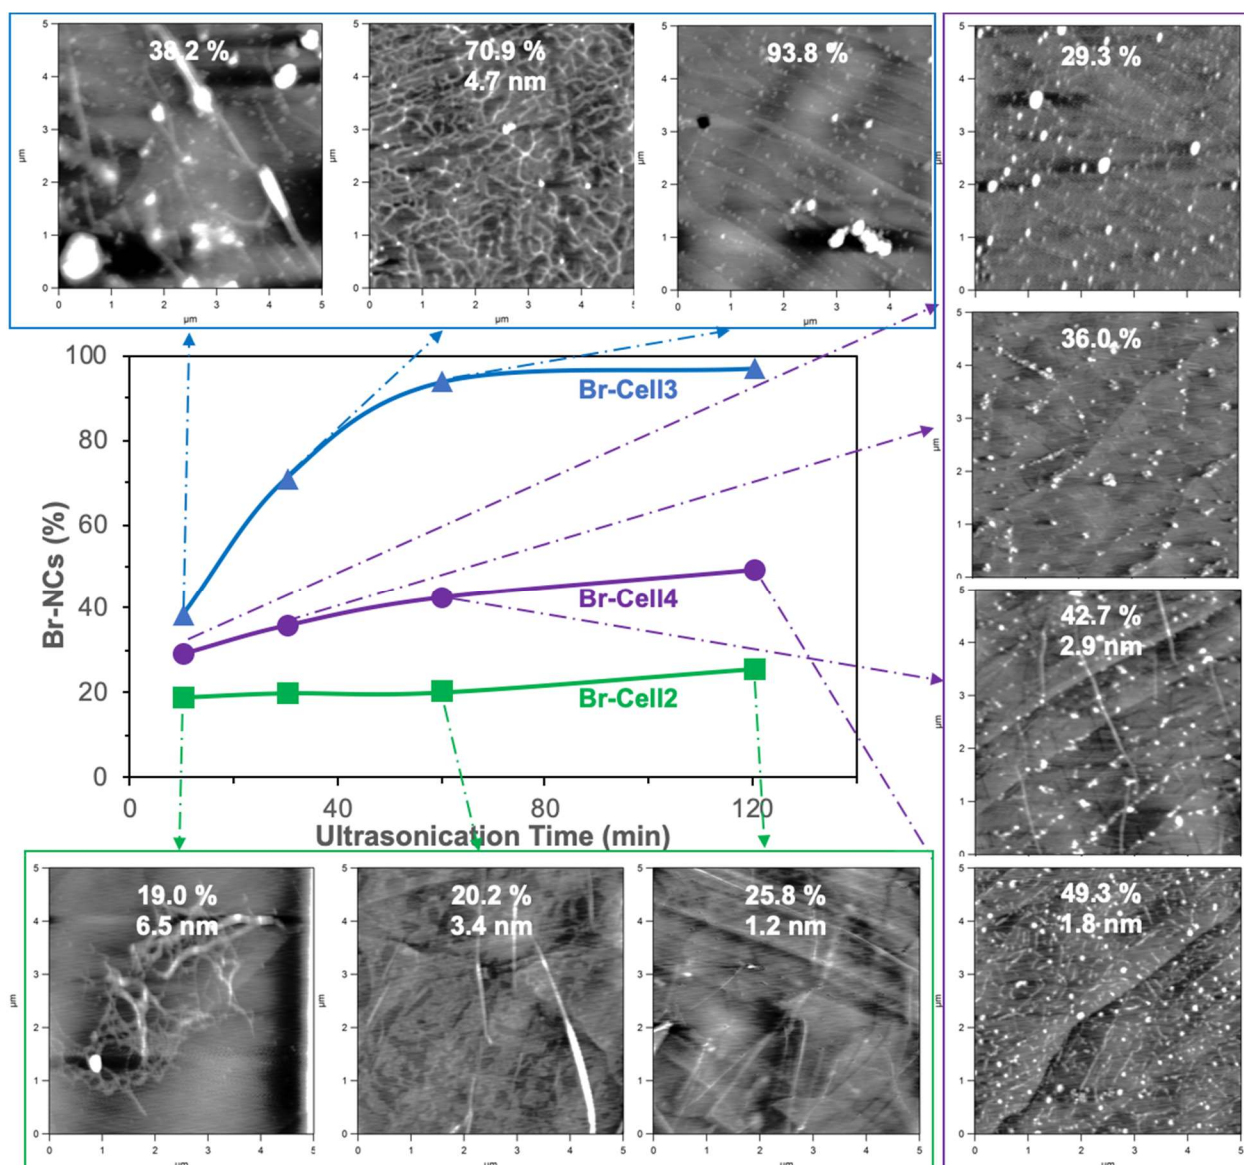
Yields and morphology of Br-NCs (5k rpm, 10 min) from ultrasonication (50% amplitude, 10-120 min) of Br-Cell2 (3.4 mmol/g), Br-Cell3 (5.7 mmol/g), and Br-Cell4 (8.7 mmol/g). AFM were imaged on highly oriented pyrophoric graphite (HOPG) with corresponding yield and Br-CNF thickness.
